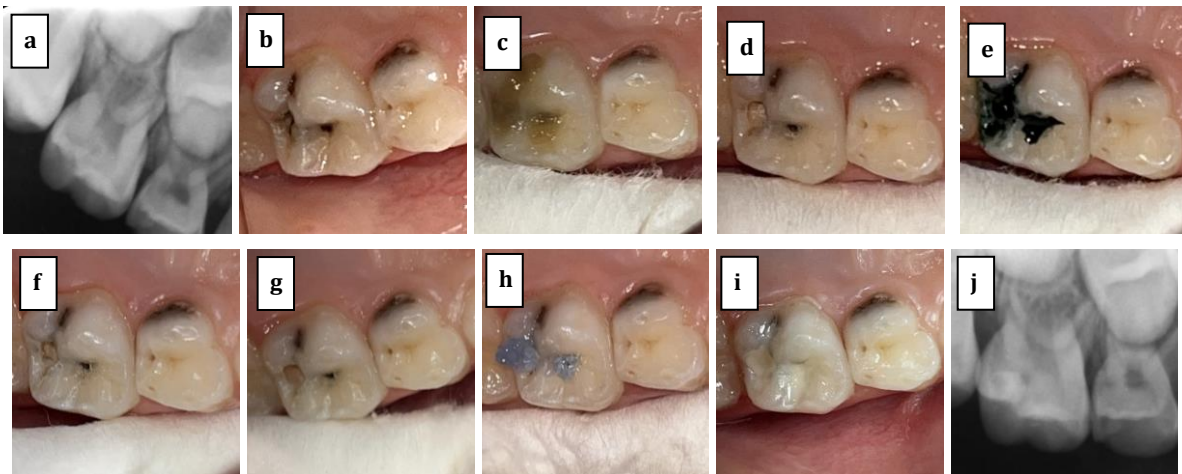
Brix 3000 application steps a. Periapical radiograph of tooth number 55 included in the study before the procedure b. Intraoral view of tooth number 55 included in the study c. Appearance of the chemomechanical agent applied to the tooth d. Gentle caries removal with the help of an excavator e. Sablee Seek caries indicator application phase f. Image after caries indicator g. Prepared state of the cavity h. Orthophosphoric acid application i. After Riva Self Cure HV and Riva Coat application j. Post-procedure periapical radiograph of tooth number 55 included in the study
